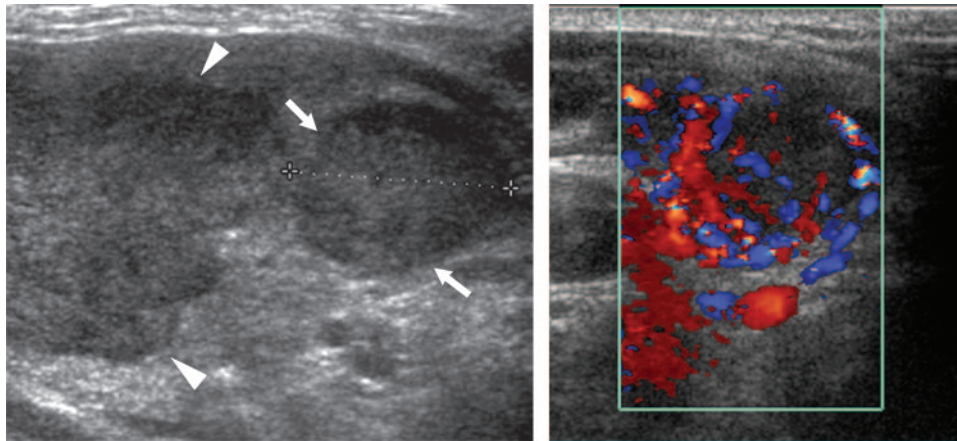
Renal cell carcinoma metastases to the thyroid in a 69-year-old woman. (a) Longitudinal sonogram of the right lobe of the thyroid shows a round hypoechoic nodule (arrows) and an irregular-shaped hypoechoic nodule (arrowheads). (b) Color Doppler sonogram of the round nodule shows increased internal vascularity.
